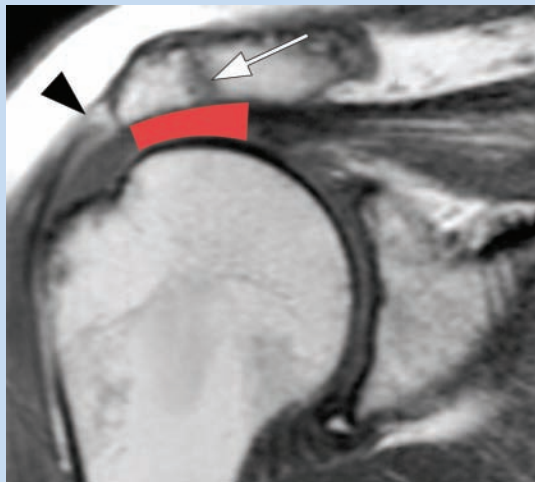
A T1-weighted coronal image in a patient with an os acromiale (arrow at synchondrosis) demonstrates the lateral deltoid attachment to the os (arrowhead). With deltoid contraction, the downward pull upon an unstable os acromiale narrows the subacromial space (red area), increasing the patient's risk for impingement syndrome.
